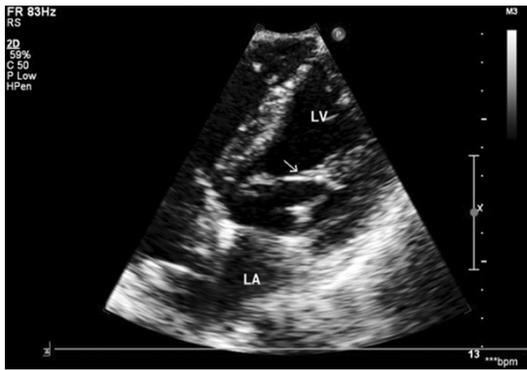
Post-operative 2D echocardiography. LV: left ventricular; LA: left atrium. White arrow indicated the artificial chordae tendineae.
